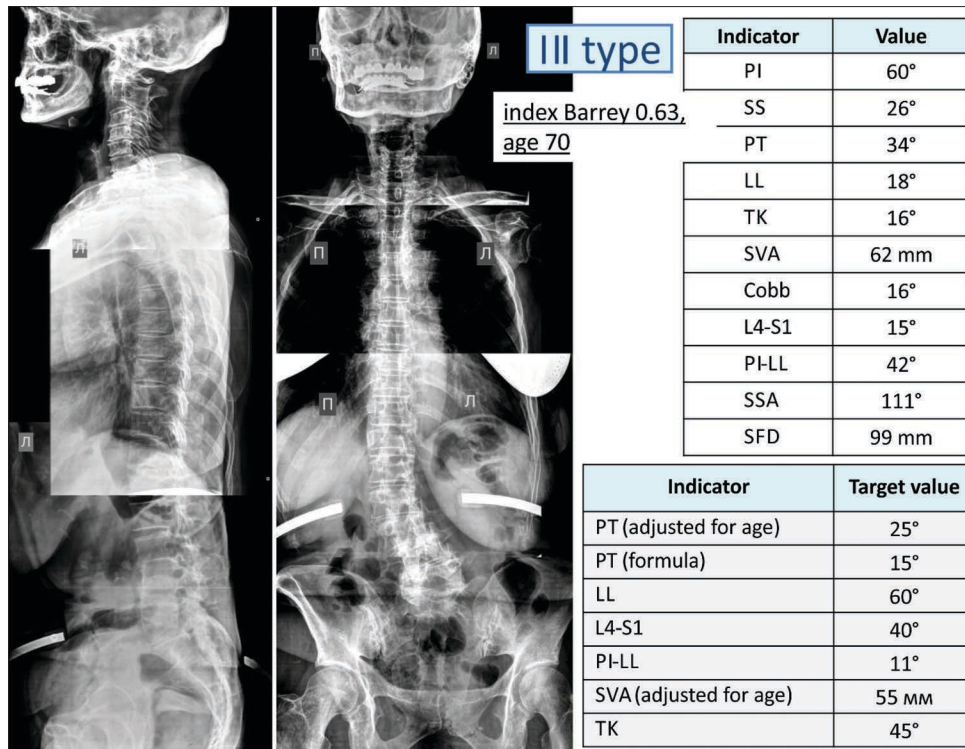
X-ray of a 70-year-old patient with adult degenerative scoliosis, frontal and decompensated sagittal imbalance, Index Barrey-0.63
